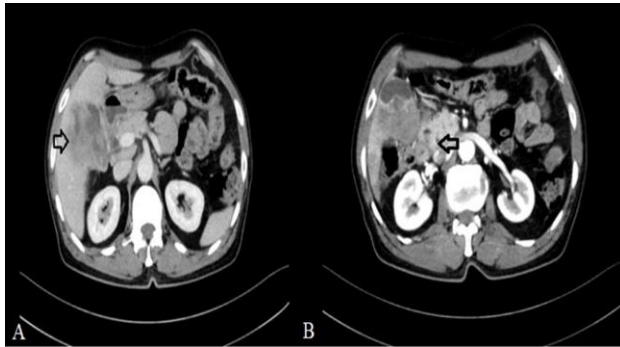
Contrast enhanced CT abdomen showing carcinoma gall bladder infiltrating into (A) liver bed (arrow) and (B) transverse colon (arrow).
